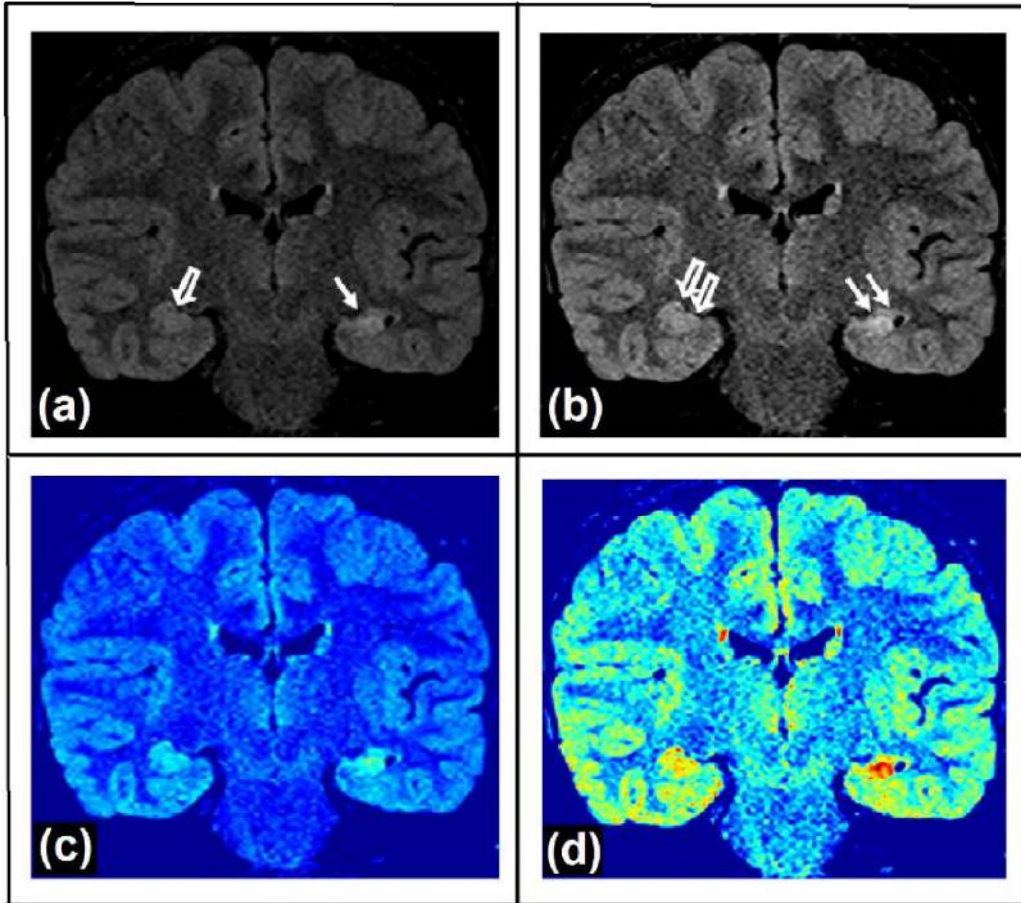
Test image 6 (left column) and MO-BA optimized SR processed (right column) coronal FLAIR images in a case of left-sided mesial temporal sclerosis (MTS) showing hyper-intense (bright) signal of the left side hippocampal formation (straight arrow) in comparison to that on the right (open arrow). Such intensity elevation forms the basis of diagnosis in MTS but remains difficult to pick-up by an eye-balling technique in routine clinical practice. The corresponding pseudo-colored image may offer some advantage as is seen in the lower panel, by showing a brighter hue of blue and white on the left side as compared to darker blue only on the right. The signal intensity and color hue difference between the pathological (double straight arrow) and the normal (double open arrow) sides in the processed images is much more convincing. Further, the thickness of the structure in this section (and hence the volume overall) is also reduced on the pathological side, appreciated with increased confidence in processed imaging.
